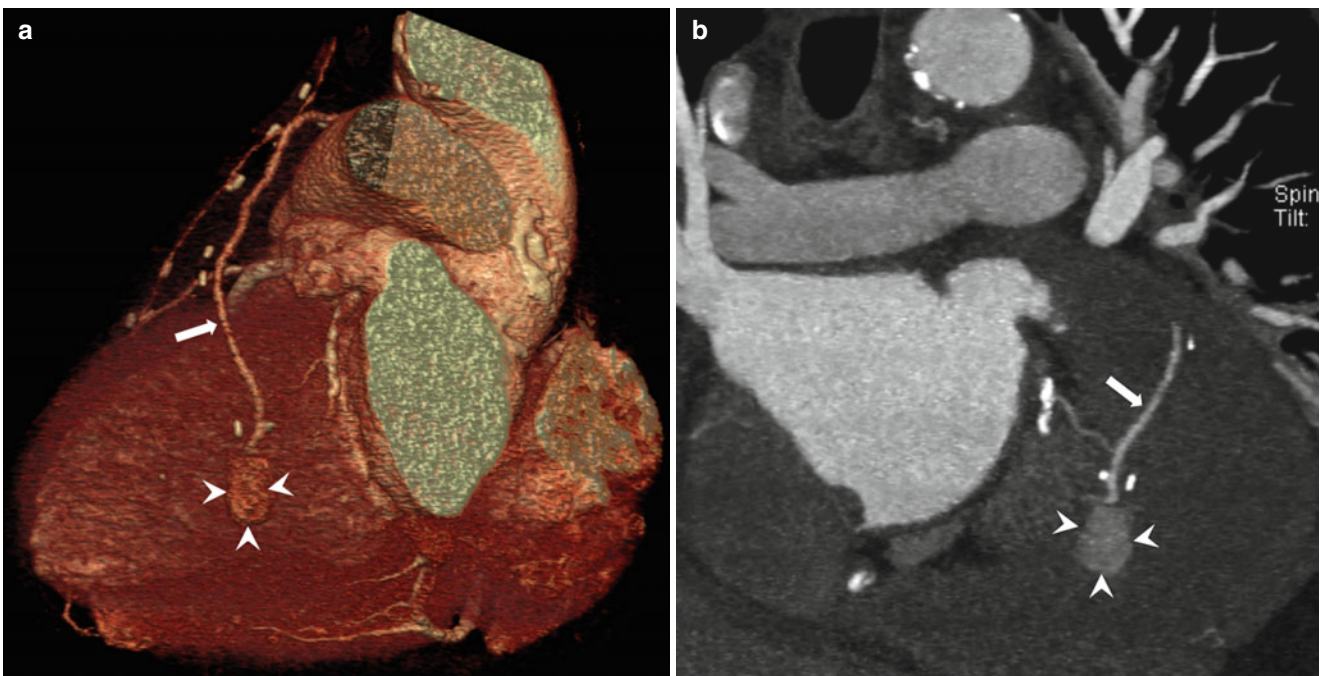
Pseudoaneurysm formation around distal anastomosis site. (a) Volume rendering and (b) oblique coronal CT images obtained at 6 months after bypass surgery showed pseudoaneurysm formation
